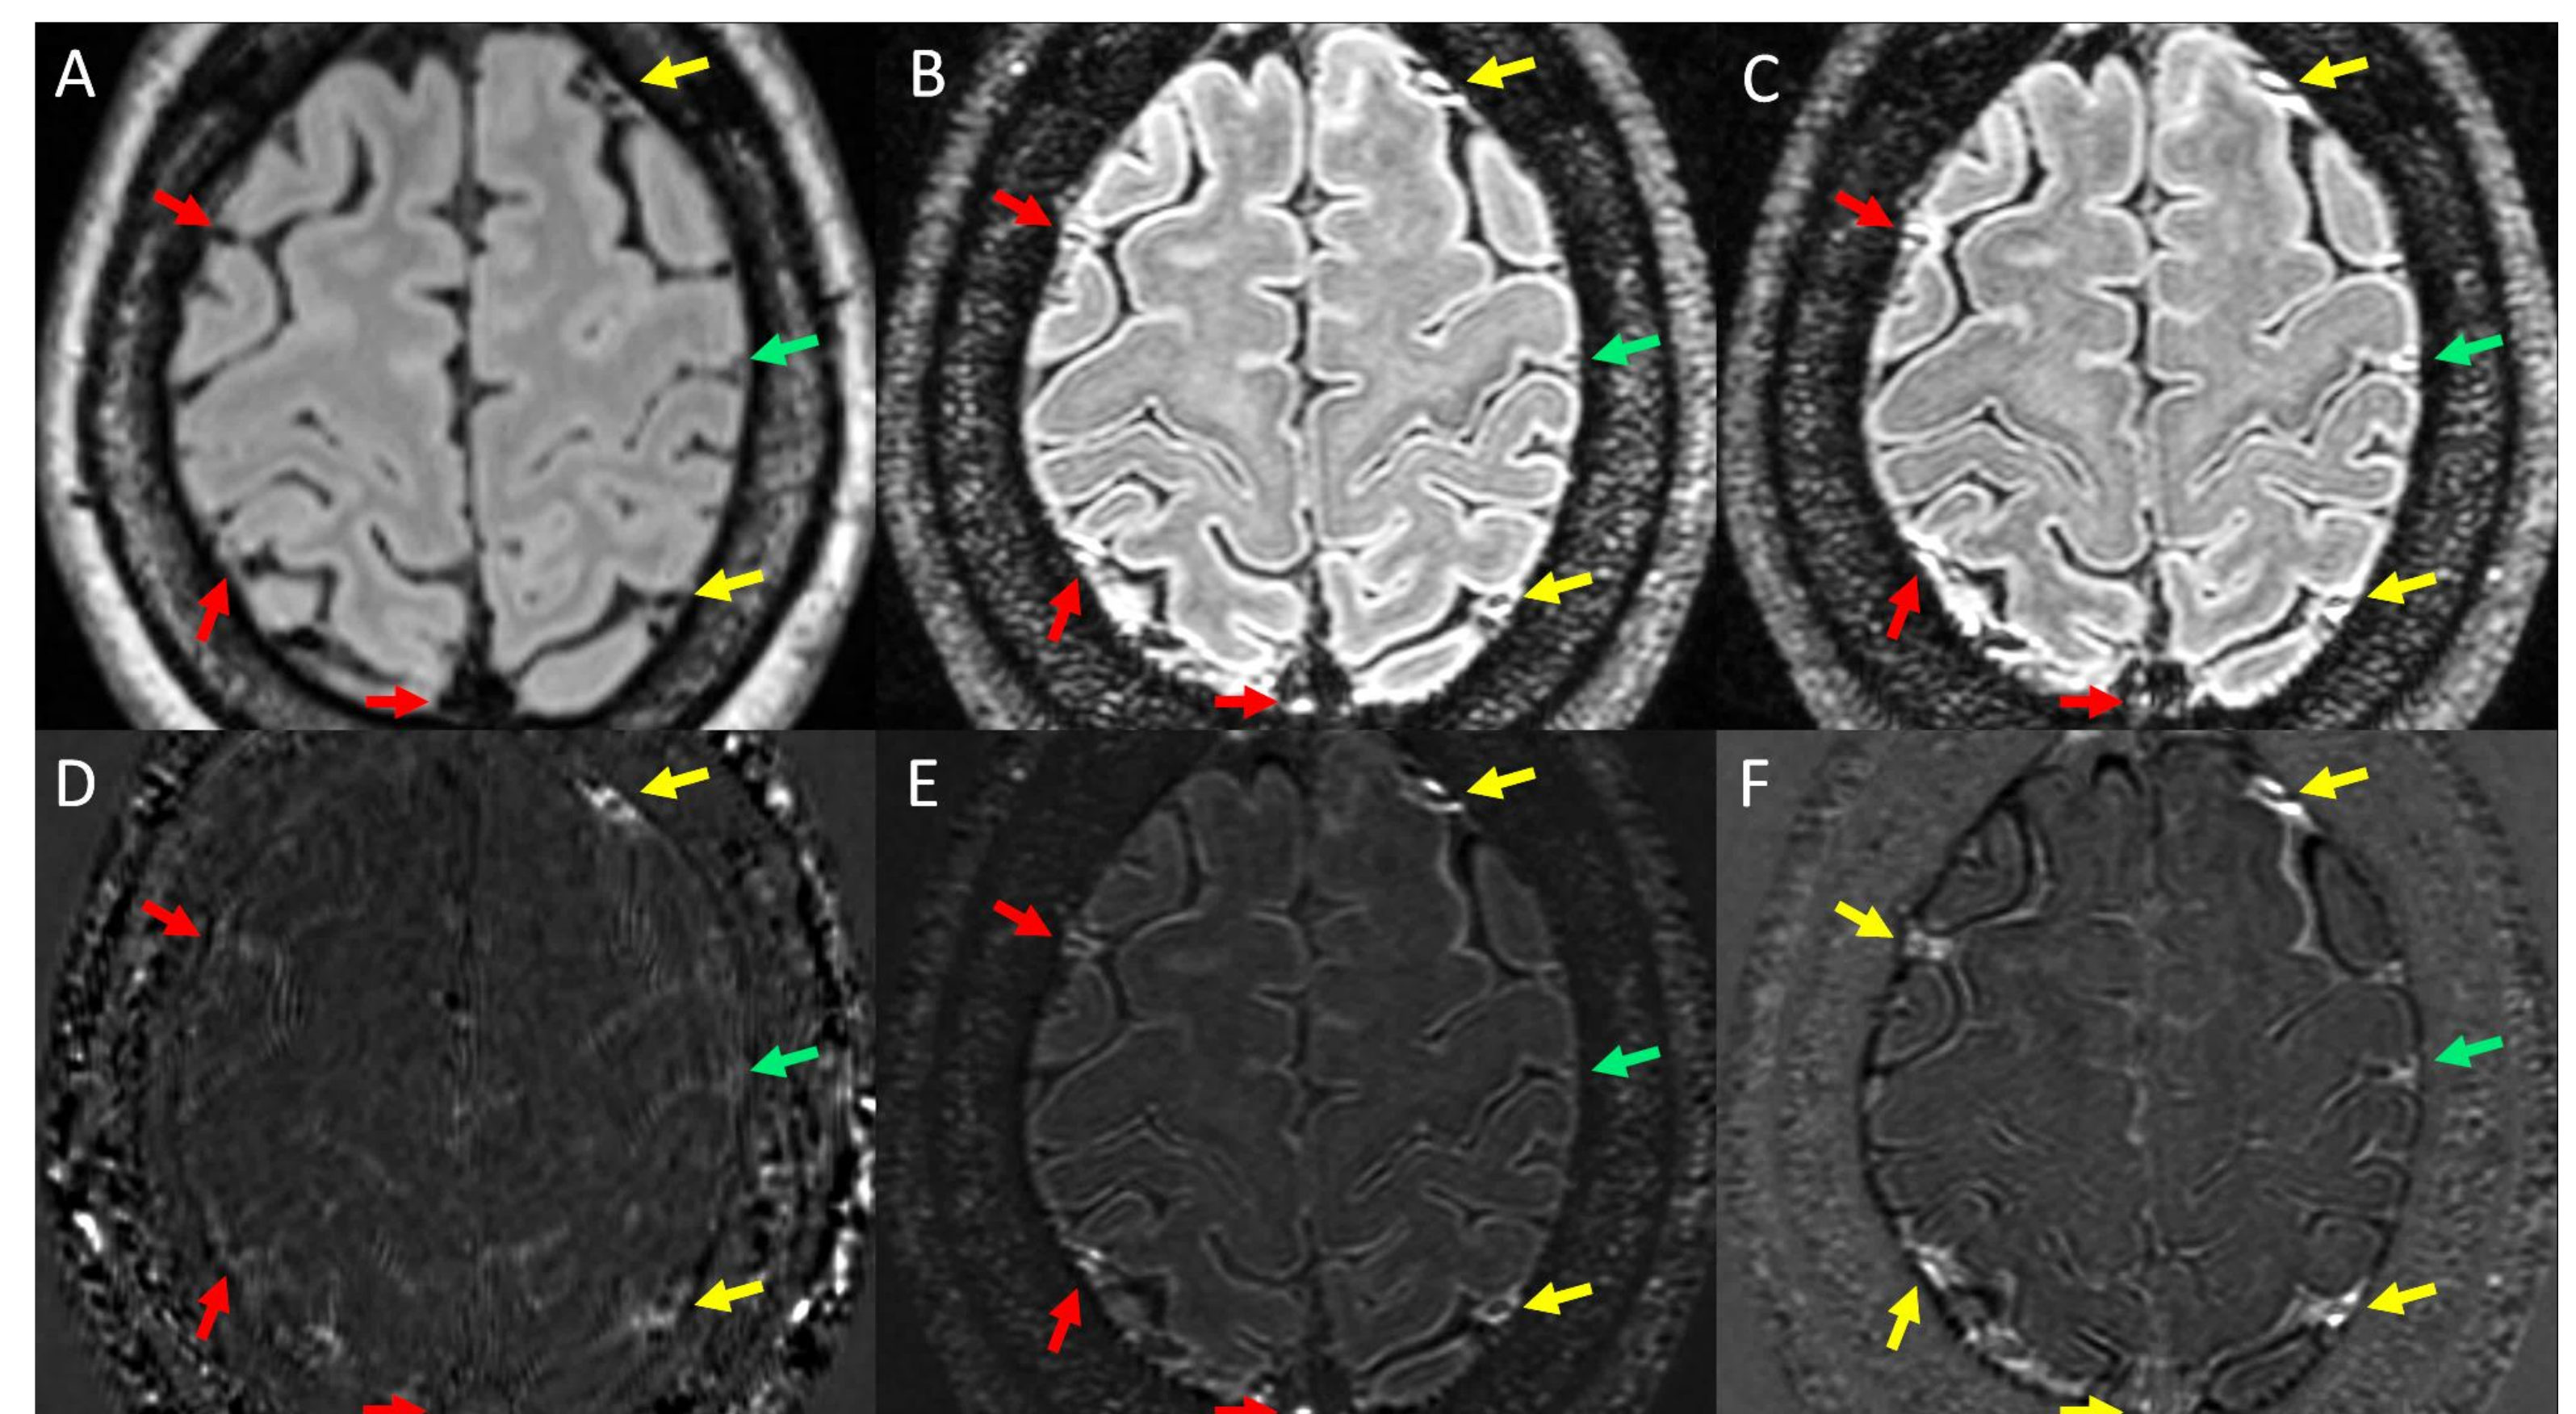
Examples of PDE as visualized on various Gd+ imaging protocols. Shown is Gd+ Delayed 3T FLAIR (A), Gd+ Early 7T FLAIR (B), and Gd+ Delayed 7T FLAIR (C). Also shown are subtraction maps associated with each (D, E, F, respectively). Yellow arrows indicate foci of PDE seen on all 3 protocols. Red arrows indicate regions where PDE was seen on both 7T protocols but not on Gd+ Delayed 3T FLAIR. Green arrows indicates a region where PDE was seen on Gd+ Delayed 7T FLAIR but could not be seen on Gd+ Delayed 3T FLAIR or Gd+ Early 7T FLAIR.
